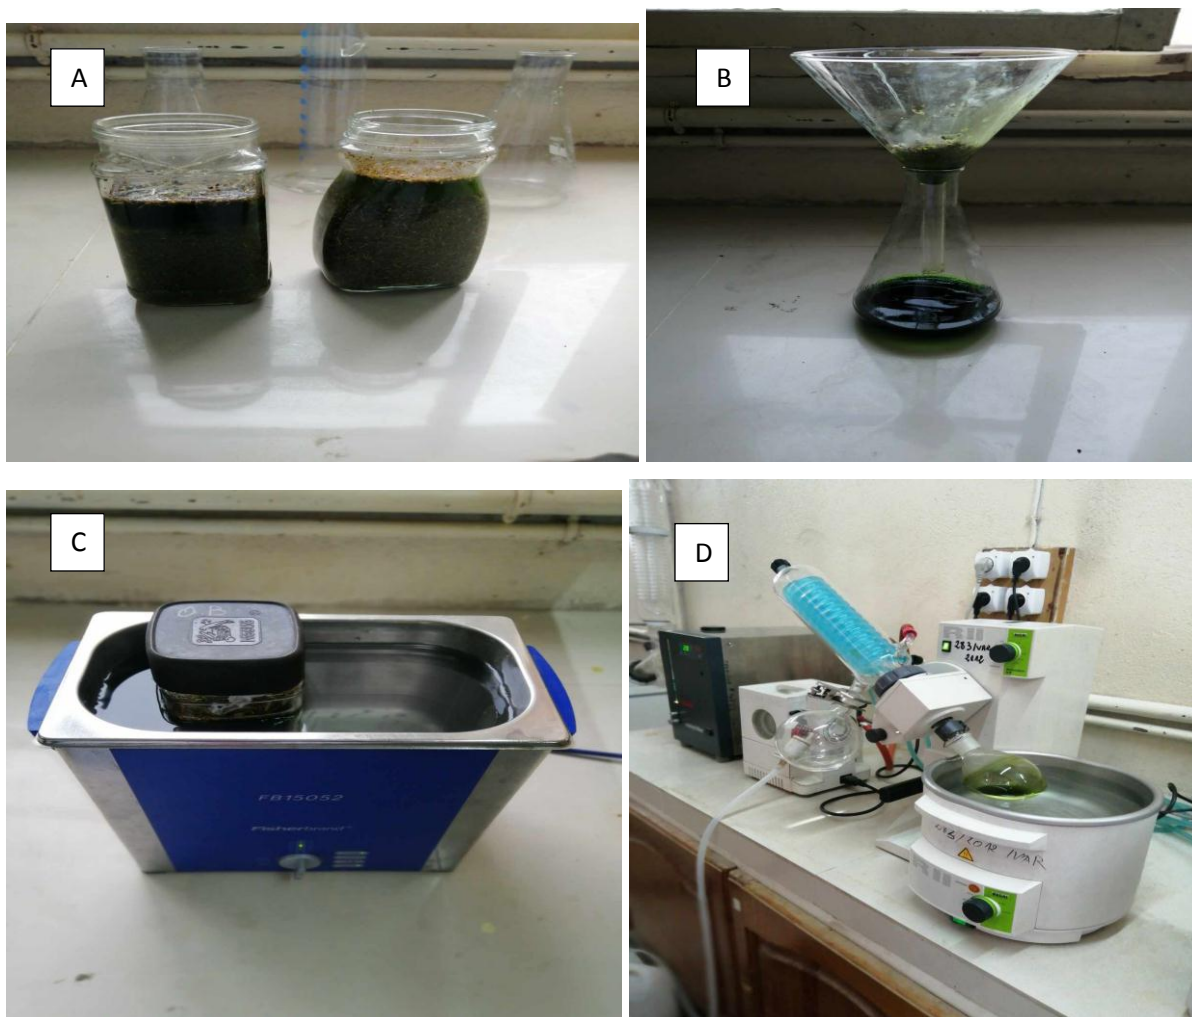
Extraction by ultrasonication of OM. A: Maceration of plants, B: filtration, C: the plants in ultrasound, D: the plants in a rotative evaporator.
